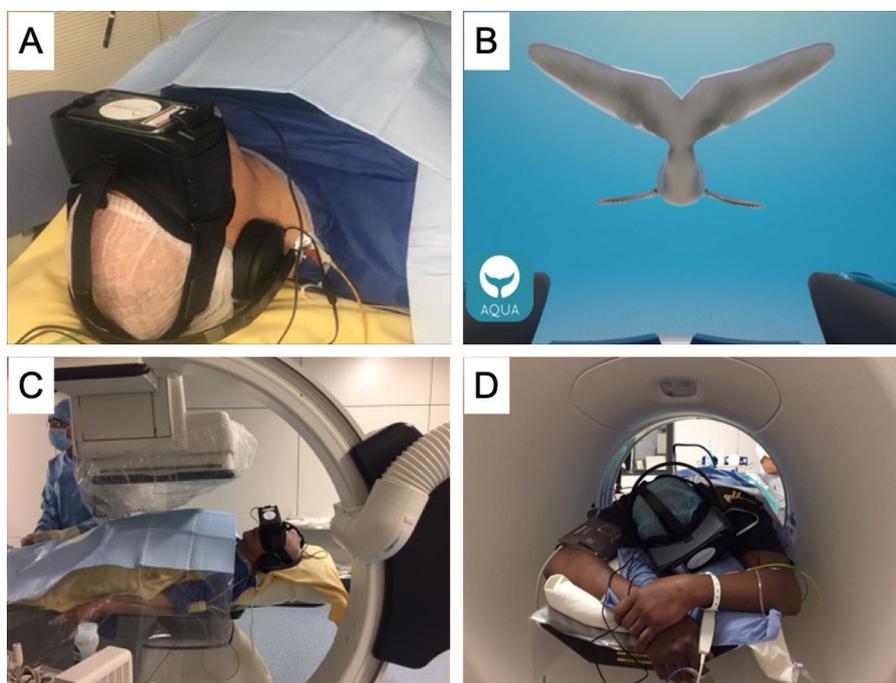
Digital sedation in interventional radiology. A. The device is composed of a virtual reality mask connected to headphones. B. Image of a sedation module projected into the mask (Aqua Module, courtesy of Oncomfort SA). The patient is invited to breath at the same pace as the whale's tail motion. C. Embolization performed under cone beam computed tomography guidance and digital sedation. The skin and deeper tissues over the artery in the groin were anesthetized with local anesthetic. D. Percutaneous computed tomography-guided renal cryoablation performed under local anesthesia and digital sedation. Patient received intravenous anesthetic as well as a paravertebral T10 nerve block. The skin and deeper tissues over the kidney were anesthetised with local anesthetic.
